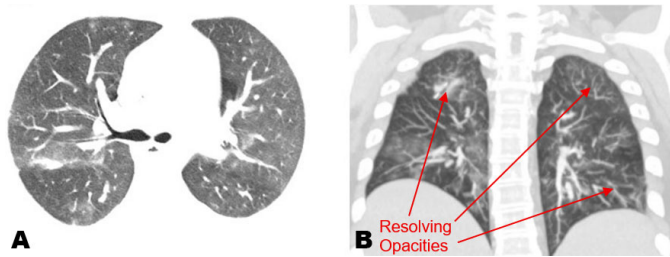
Follow-up computed tomography (CT) of the chest demonstrating resolving bilateral ground-glass opacities after immunosuppressive treatment: (A) axial view and (B) coronal view.
